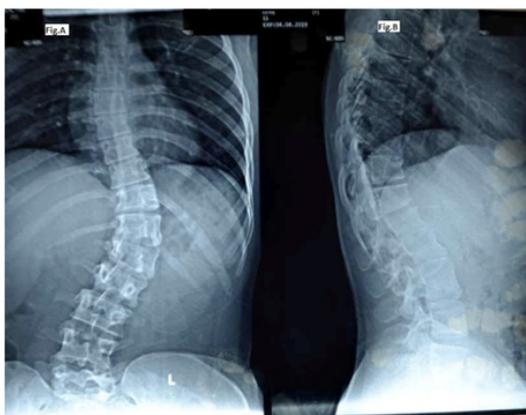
Preoperative standing PA and lateral radiographs of a 17 years old girl showing Lenke type 5C AIS curve.
